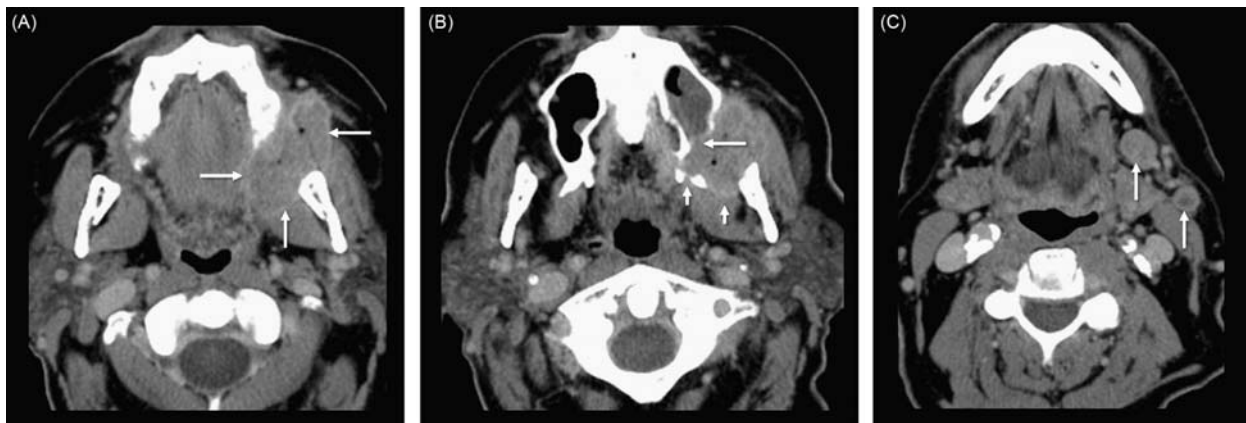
Squamous cell carcinoma of the left retromolar trigone (RMT), T4b N2b. (A) Axial contrast-enhanced CT demonstrates large tumor centered in the left RMT (arrows). (B) Axial contrast-enhanced CT (cranial to A) shows obvious invasion of the posterior maxilla involving the maxillary sinus (long arrow) from tumor growing superiorly along the pterygomandibular raphe. Tumor is therefore upstaged to T4a. Also note tumor extension to medial pterygoid plate and masticator space (short arrows), resulting in overall T4b stage. (C) Axial contrast-enhanced CT shows metastatic level I and II nodes (arrows). Some have central low density, a very specific sign for metastasis. From Aiken, A. H. (2013). Pitfalls in the staging of cancer of oral cavity cancer. *Neuroimaging Clinics of North America* 23(1), 27–45.
